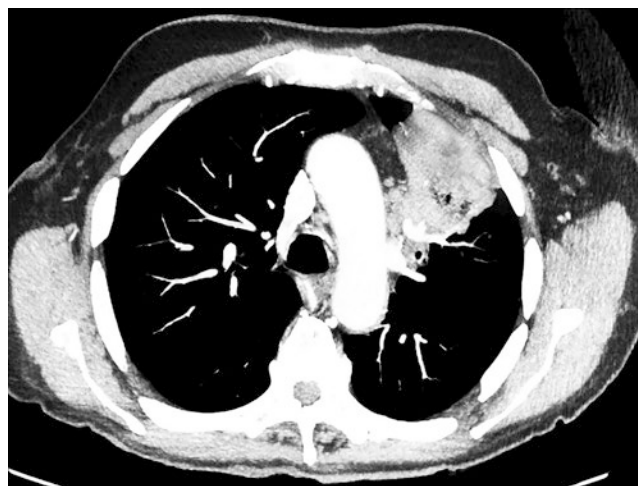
CT image of a large mass in the left upper lobe of the lung with pleural involvement
